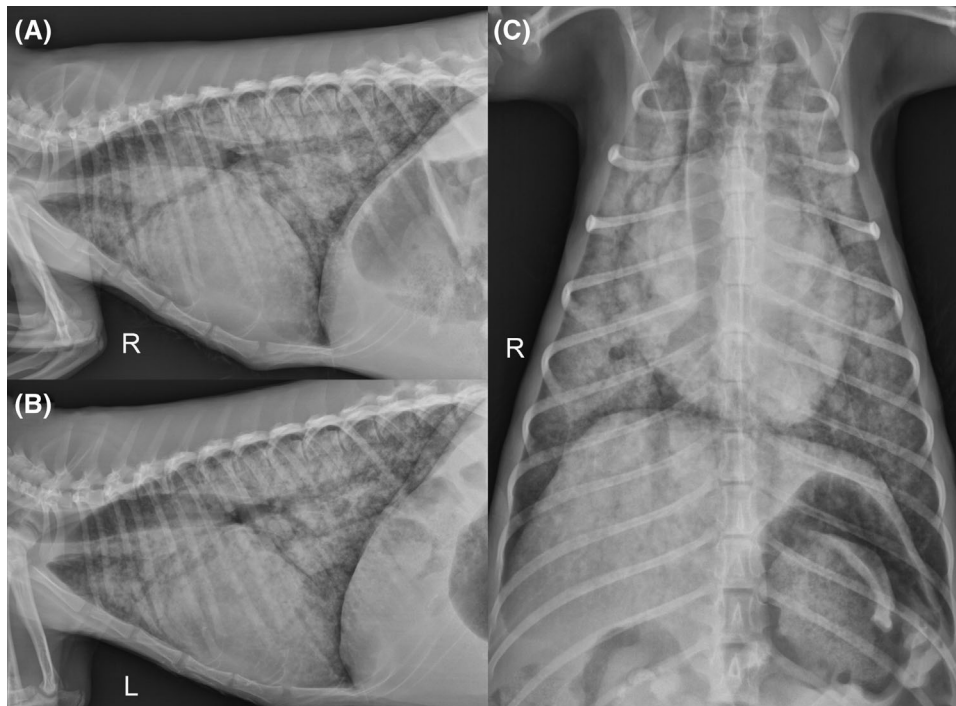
Right lateral (A), left lateral (B), and dorsoventral (C) thoracic radiographs of a 14-month-old red kangaroo (*Macropus rufus*). The cardiac silhouette is subjectively mildly generally enlarged. The lung has a severe diffuse mixed pattern, characterized by a diffuse alveolar pattern superimposed on a bronchial pattern. Technique 121 kVp and 5.6 mAs, CXDI-50G, Canon Medical Systems USA, Inc., Tustin, CA
